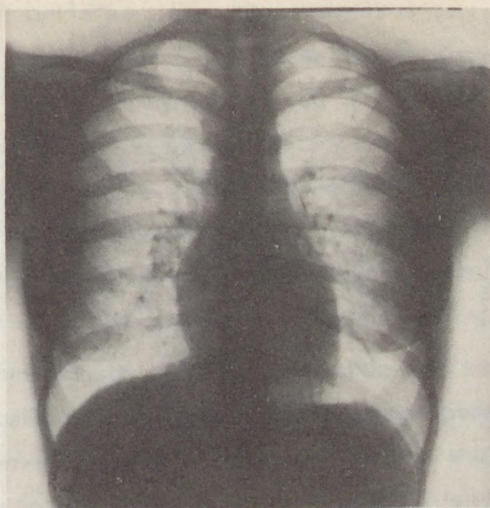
Thoracic X-ray picture of M.J. (case 2) on day 5 of treatment
